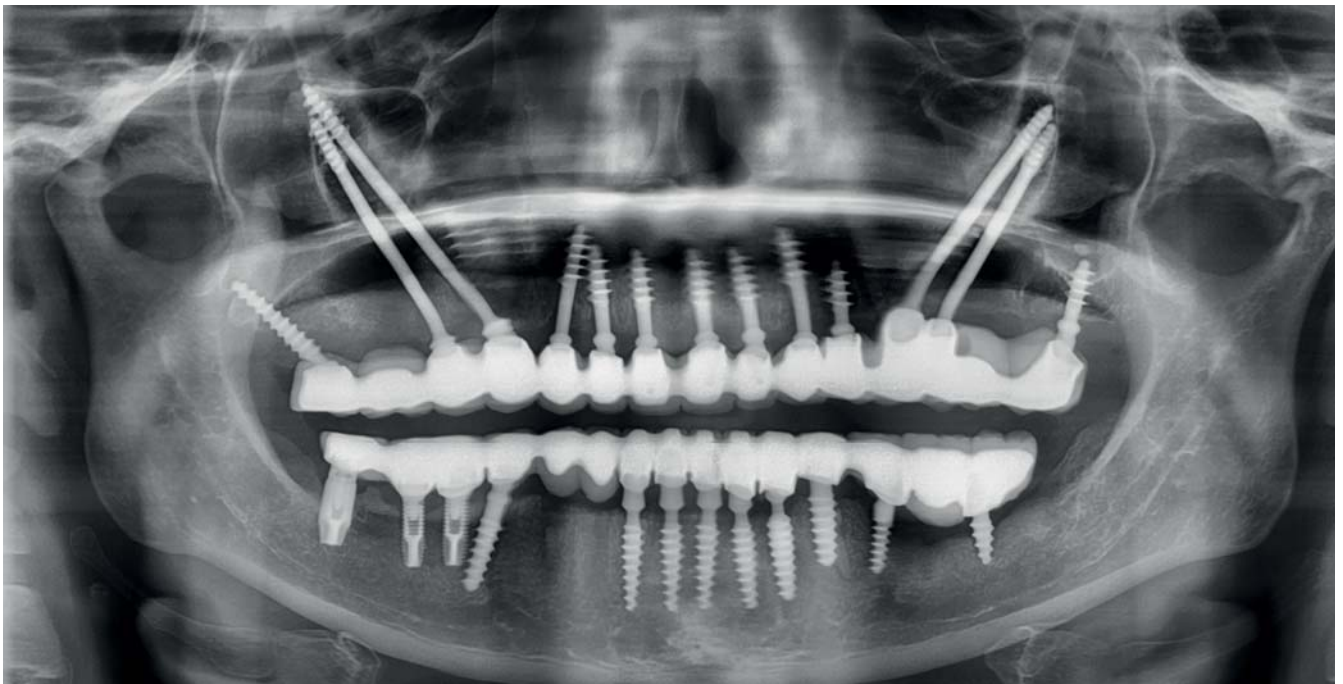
View of the control orthopantomography with the placed prosthesis. Distal cantilevers must be left without any occlusal and masticatory contact however.
